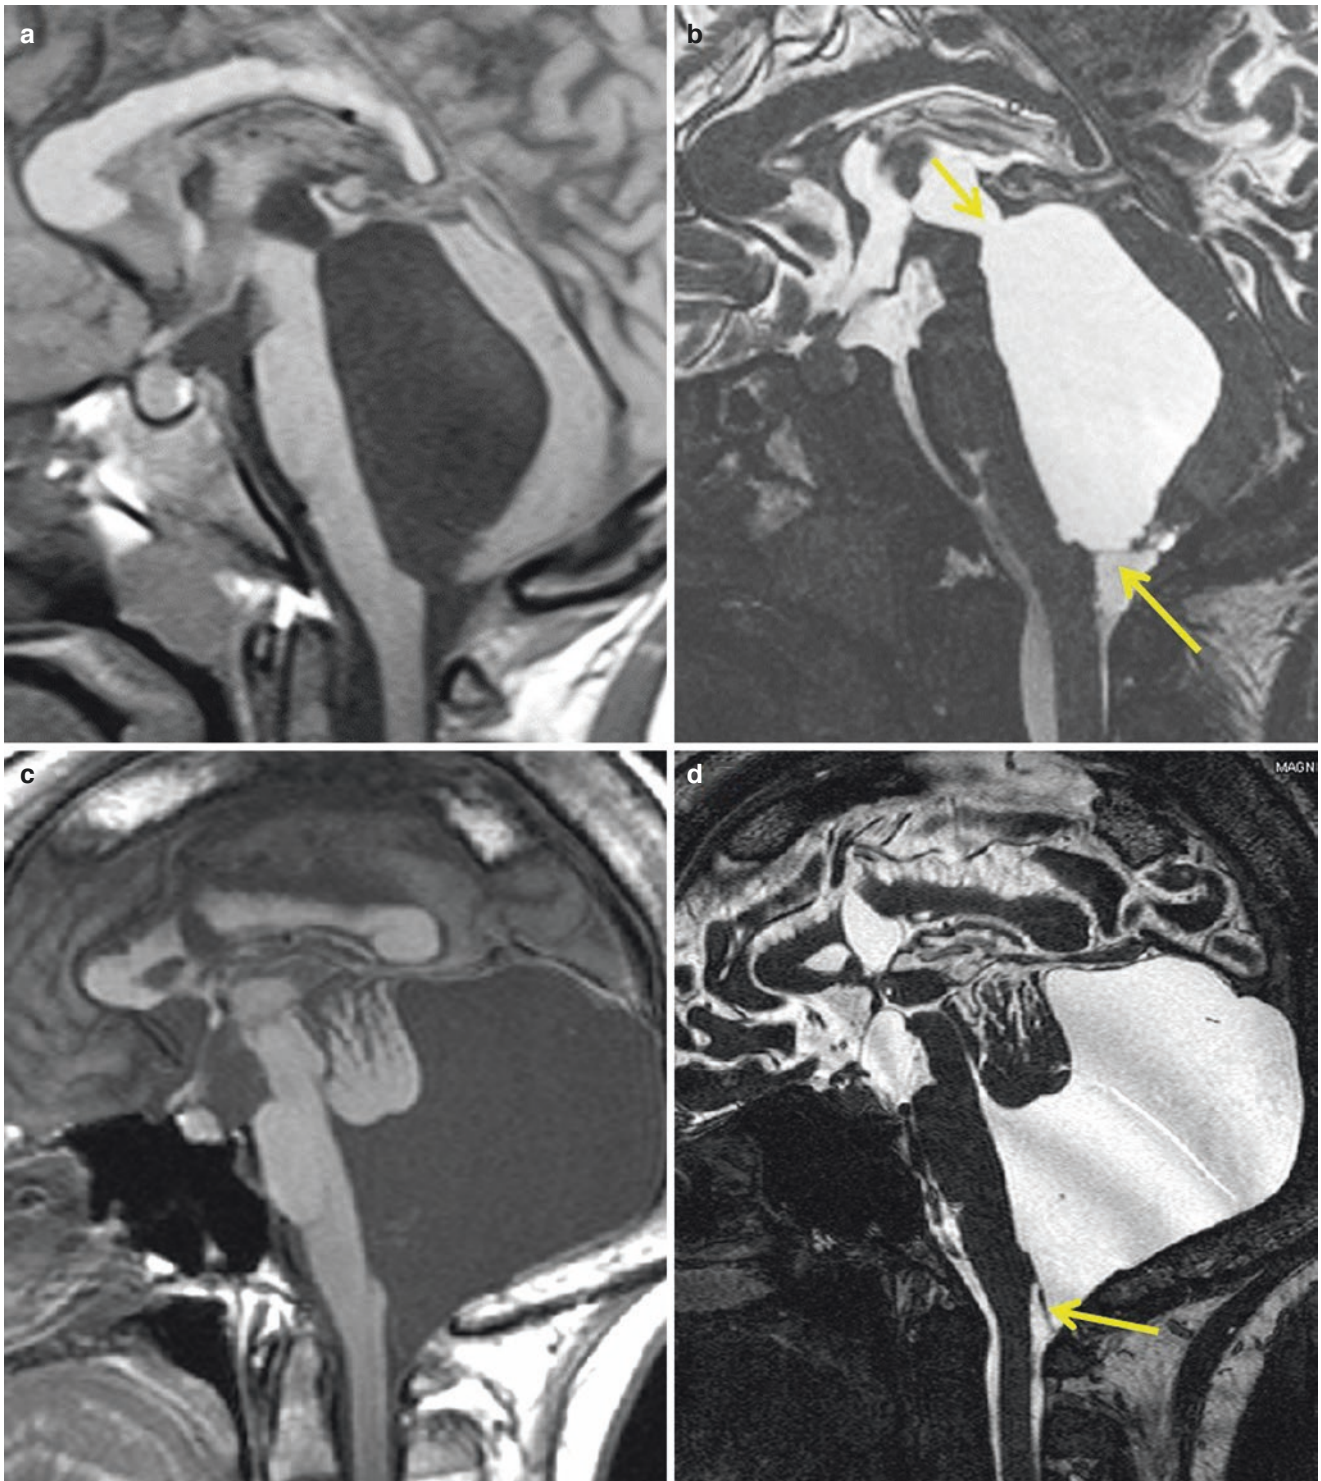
Fourth ventricle hydrocephalus. Non-communicating hydrocephalus secondary to inflammatory obstruction of the fourth ventricle outlets (trapped fourth ventricle) in patients with history of perinatal infection. Sagittal T1-weighted (a) shows marked isolated fourth ventricle enlargement. The high-resolution 3D CISS images (b) shows thin bands that blocked the CSF pathways of the fourth ventricle, including foramen of Magendie, and aqueduct (arrows). Non-communicating
